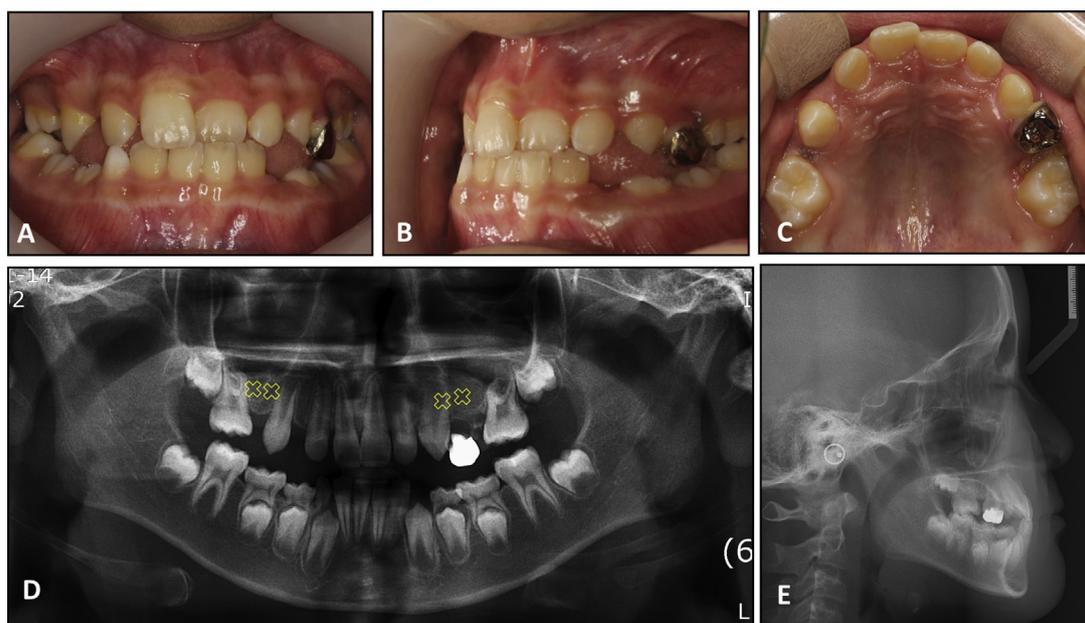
Pretreatment examination. A-C, intraoral view, and D, pretreatment panoramic radiography show ankylosed lower deciduous molars and congenitally missing upper four premolars. E, Pretreatment lateral cephalogram (10 years of age).
